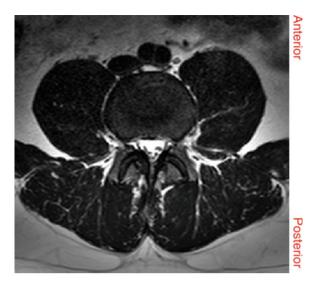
Axial T1-weighted MRI showing anterior and posterior terms [5]
